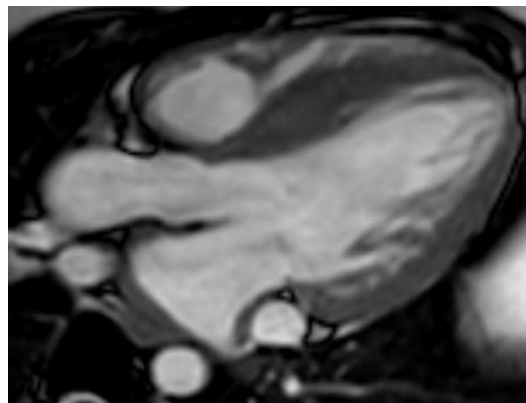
Cardiac MRI of Non-compaction CMP
